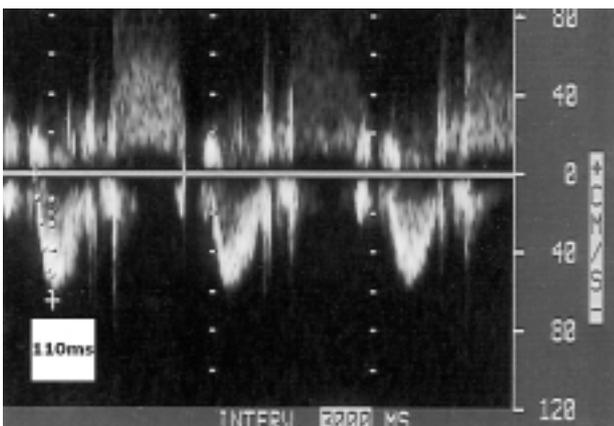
Doppler findings: a right ventricular acceleration time of 110 ms (normal) was obtained using pulsed wave Doppler with the sample placed within the right ventricular outflow tract (left panel); the Doppler signal of the tricuspid regurgitant jet was obtained by continuous wave Doppler from the apical 4-chamber view; the peak velocity measured approximately 2.0 m/s giving an estimated systolic pulmonary pressure of 26 mmHg (assuming that the right atrial pressure equals 10 mmHg; right panel).
